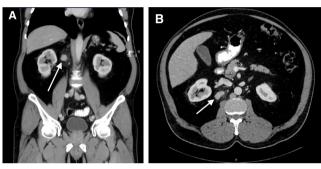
A: Coronal plane of abdominal CT scan (lipid dense mass shown with the arrow). B: Transverse plane of abdominal CT scan (lipid dense mass shown with the arrow).
